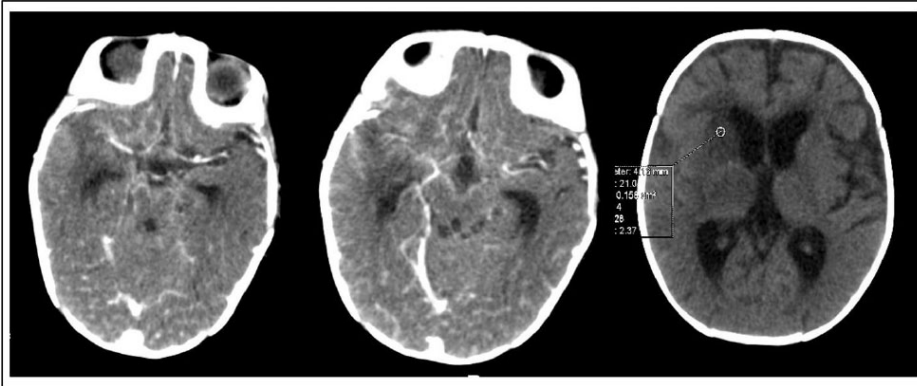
Head computed tomography scan with contrast in the axial plane showed basal meningeal enhancement (left, middle), and head computed tomography scan without contrast in the axial plane showed unilateral hypodensity in the right thalamus and basal ganglia (right) and hydrocephalus.
